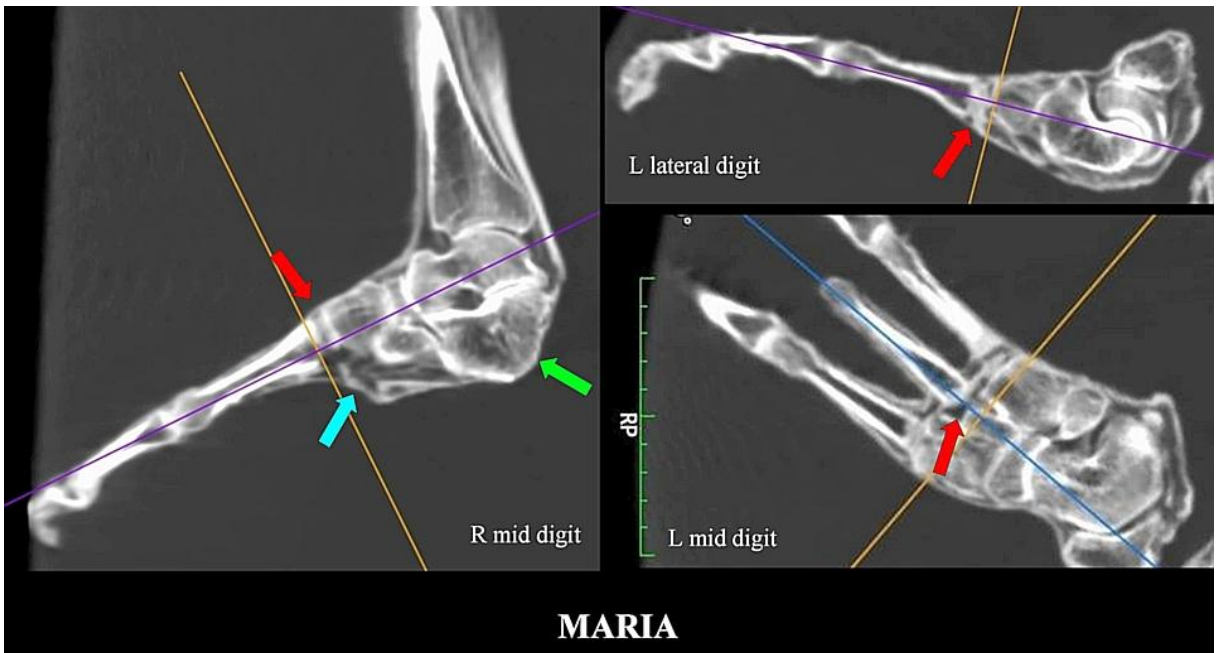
Oblique plane multi-planar 2D CT reconstruction along digits showing the intact joints between digits and tarsal bones (*red arrows*). Note the shortening of the calcaneum with thinning of cortex posteriorly (*green arrow*) suspicious of previous bone truncation. Note the transition of thick soft tissue on the under-surface of the foot to the thin soft tissue of the digit (*blue arrow*).
